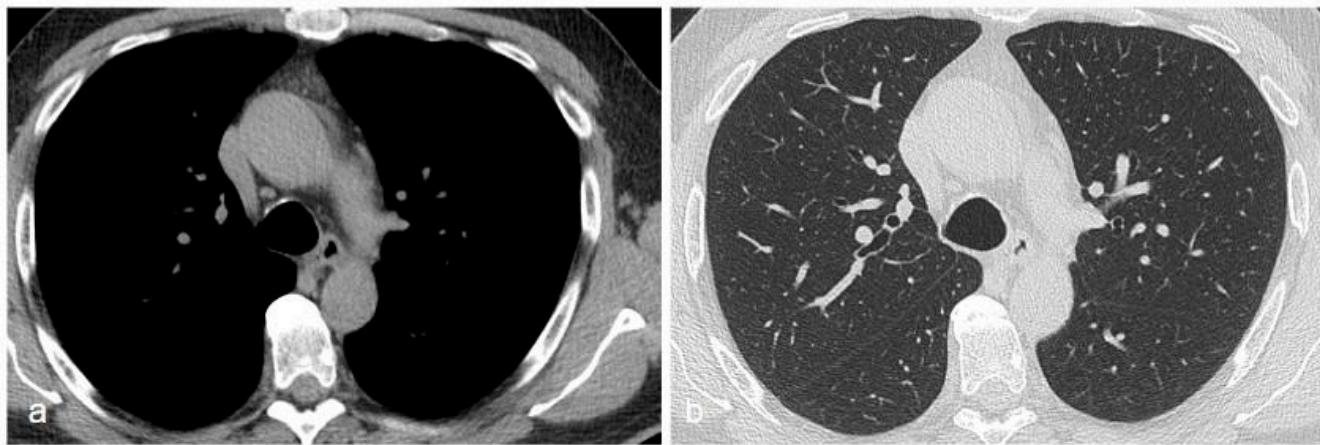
(a) Mediastinal window showing a grade 2 T score, with approximately 50% of the thymus with fatty involution and 50% characterized by soft-tissue-attenuated tissue. No pulmonary alterations are visible on the lung parenchyma CT reconstruction (b).
